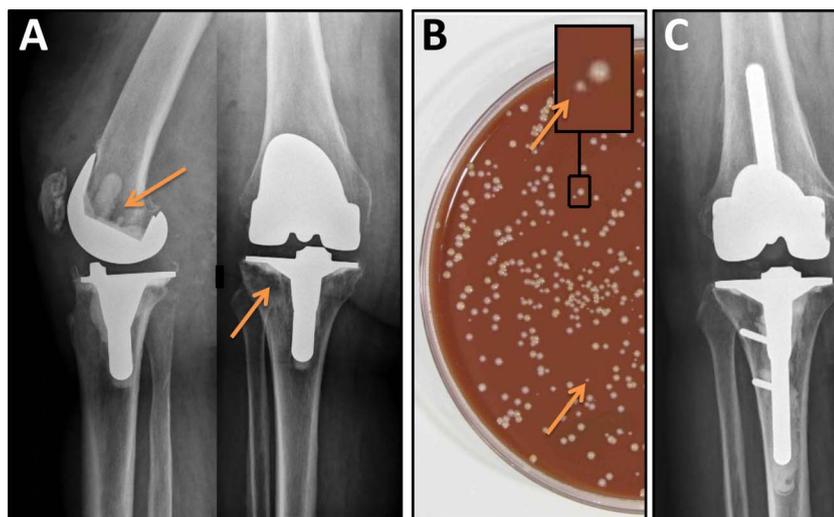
Periprosthetic pathological lucencies (A, arrows), associated with MSSA SCV in cultures (small colonies) obtained with sonication from prosthesis explantation (B, arrows). After reimplantation and a total of 3 months of antimicrobial therapy, no relapse occurred at 1 year (C, x-ray).
